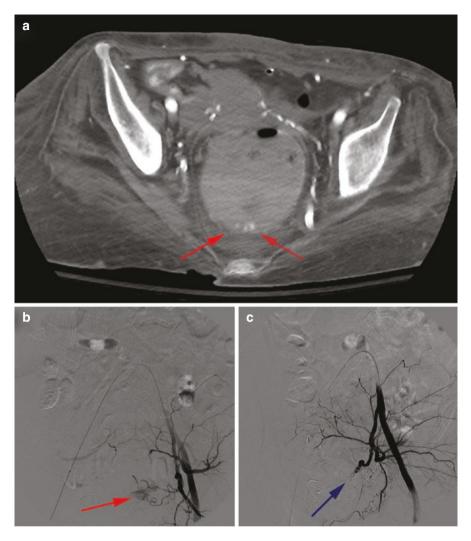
Bleeding and intervention in a chronically constipated patient with stercoral ulcer. (a) CTA demonstrating active extravasation of contrast in the dependent portion of the rectum (red arrows), indicative of active lower GI bleeding. (b) Digital subtraction angiography images demonstrating active extravasation of contrast (red arrow) from the left middle rectal artery. (c) Digital subtraction angiography images demonstrating cessation of bleeding (absence of blush) after coil embolization of the left middle rectal artery (blue arrow)
